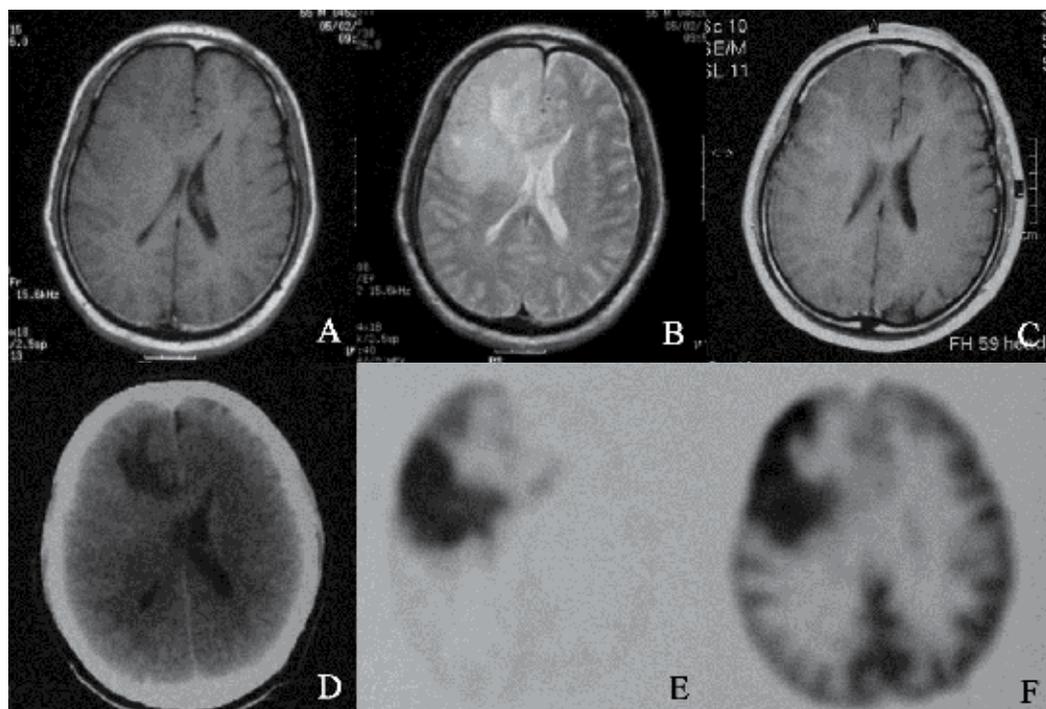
A 55-year-old man with a diffuse lesion in the right frontal lobe. A-C: T1-weighted (A) and T2-weighted (B) magnetic resonance (MR) images, and T1-weighted MR image with contrast medium (C), showing a mass in the right frontal lobe with unclear margin as slightly hypointense on the T1-weighted and hyperintense on the T2-weighted images, with some slightly enhanced spots in the lesion. D: Computed tomography scan, showing the lesion as equal or slightly increased density, with an unclear border, in and below the right frontal lobe cortex. E: ^{11}C -methionine positron emission tomography (PET) scan, showing an irregular area of high uptake with a clear border in the right frontal lobe. The area of highest MET uptake was in the posterior part of the lesion. F: ^{18}F -fluorodeoxyglucose PET scan, showing an irregular area of high uptake which was relatively well defined in the frontal lobe. The highest FDG uptake area was in front of the MET hot area.
